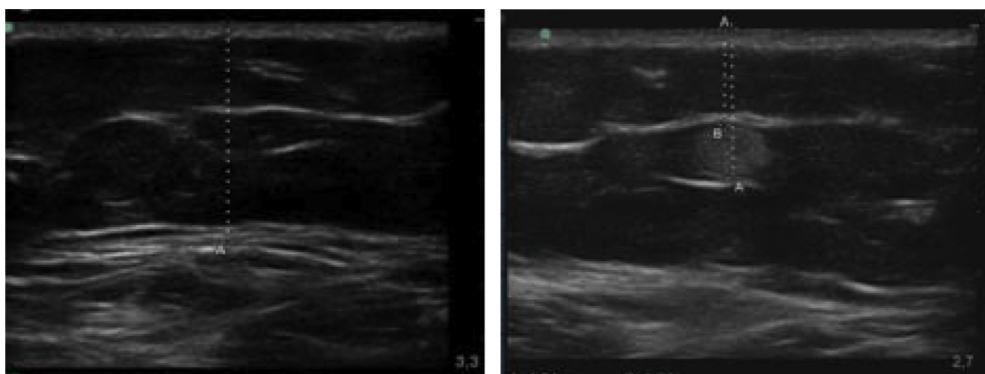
Ultrasonographic images of the skin of an overweight female subject before (left) and after (right) injection of 0.3 mg adrenaline using the Anapen autoinjector. The dotted line and letter A denote the skin limit (left) or the bolus localization (right).
